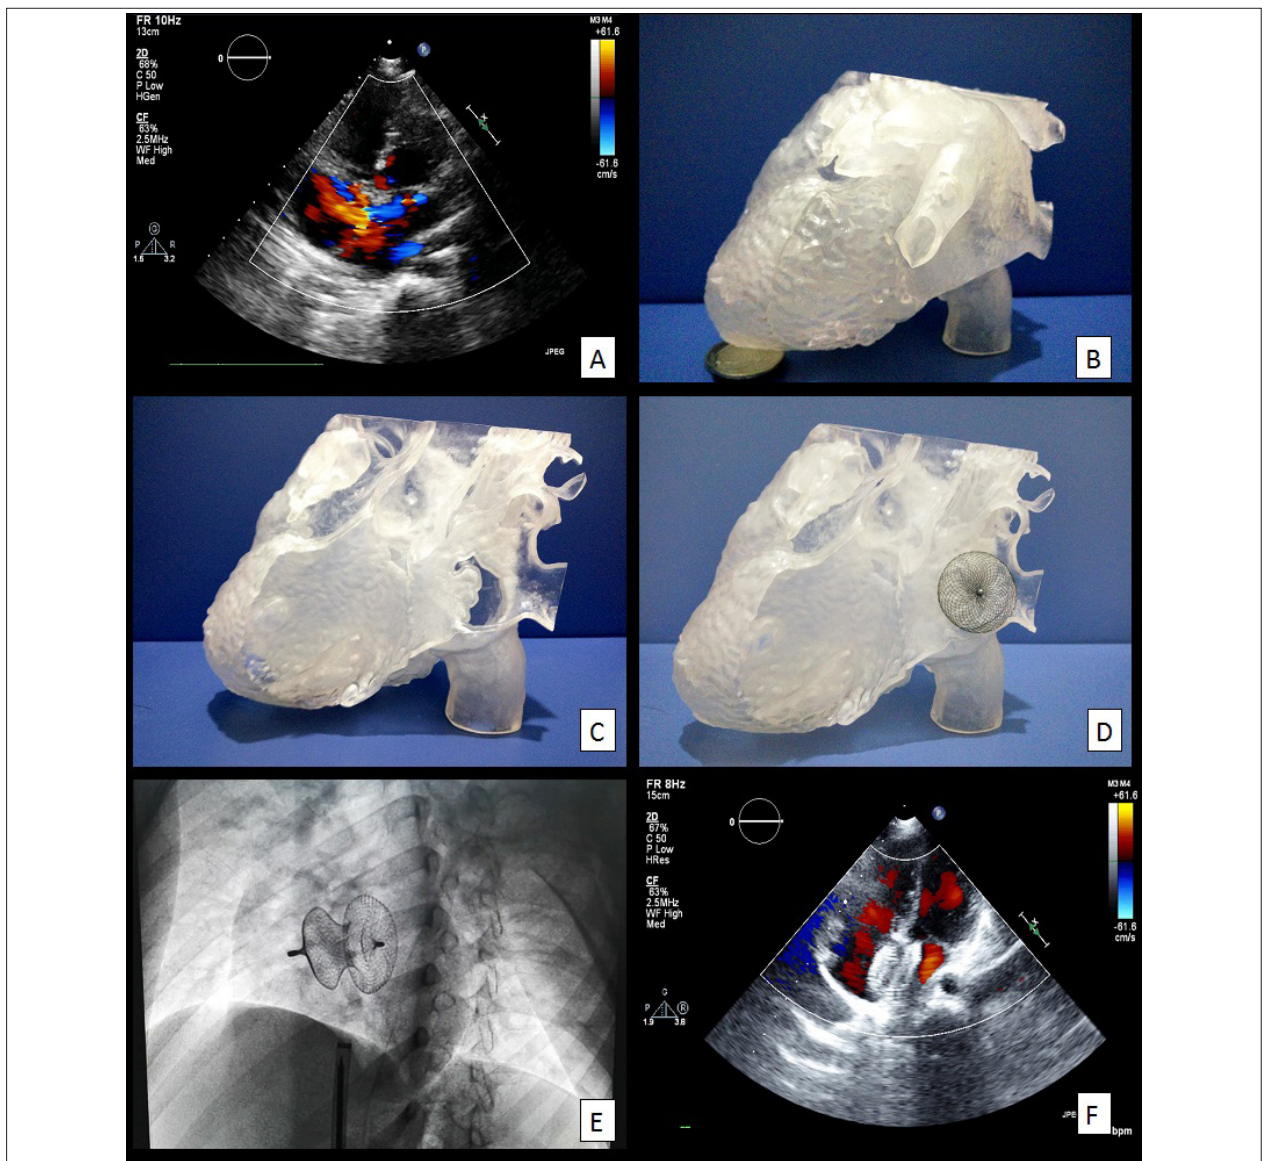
Echocardiographic apical four-chamber axis view showing a 15-mm ASD with left-to-right shunt (A). Three-dimensional printing cardiac model in whole view (B) or being separated to show the ASD (C). A 28-mm occluder was placed to completely cover the ASD (D). Intraoperative placement of a 28-mm ASD occluder after one trial (E). Postoperative echocardiographic apical four-chamber axis view showing no left-to-right shunt (F).
